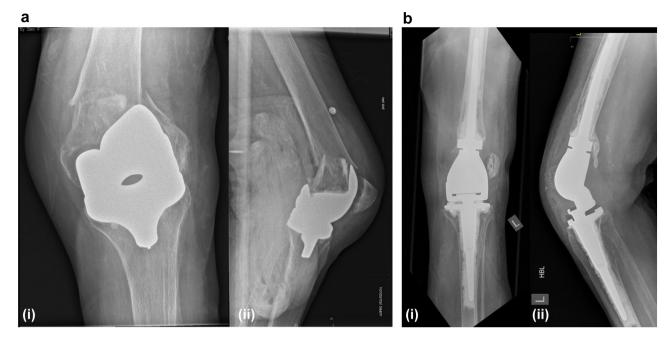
(a) Preoperative anteroposterior (i) and lateral (ii) radiograph of left knee with comminuted periprosthetic fracture in an 85-year-old female. (b) Anteroposterior (i) and lateral (ii) postoperative radiographs at 9 months follow-up with patella dislocation.
